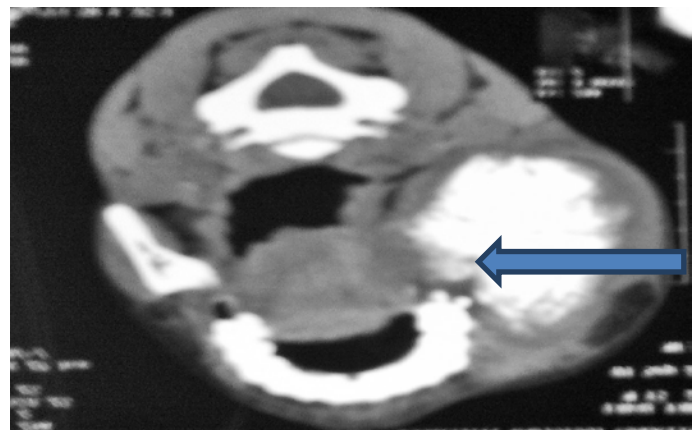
Axial non-contrast enhanced CT of the face, showing an extensive, destructive, irregular, hyperdense left mandibular mass involving the bony cortex and the medulla with extension into the adjacent soft tissue. Spiculation of the outer cortex of this mass gives the classical sun burst appearance seen in osteosarcoma (blue arrow).
